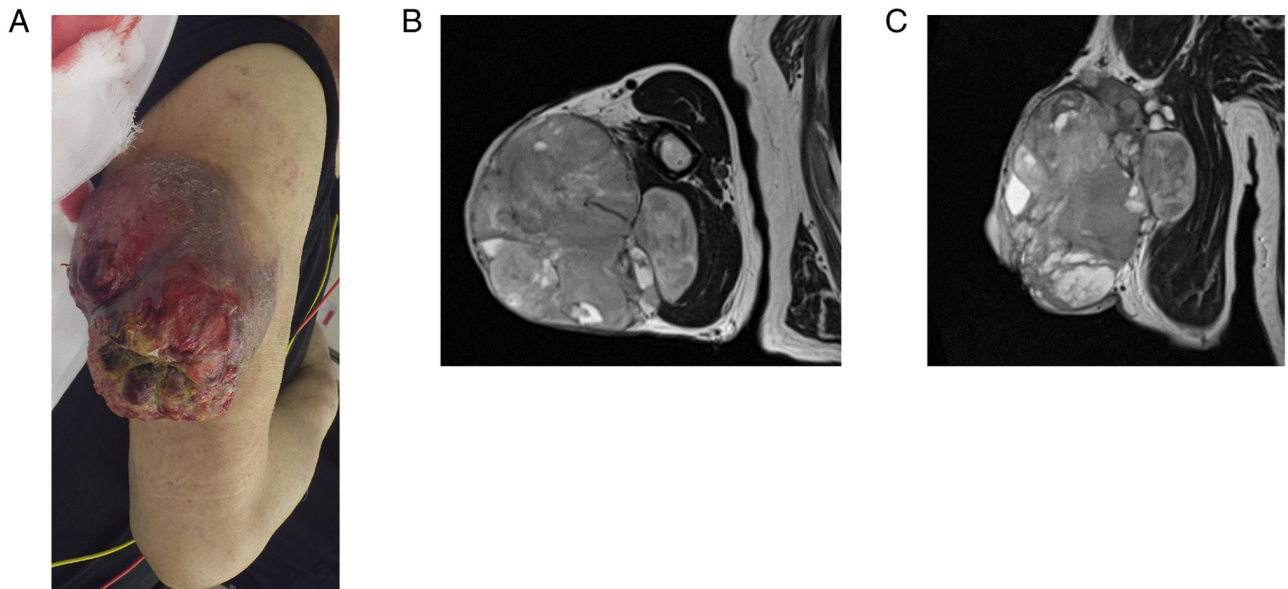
A 78-year-old man with malignant wound from a myxofibrosarcoma in the upper arm. (A) He had a large tumor in his right upper arm with odor and exudate on the wounded overlying skin. (B and C) MRI revealed a mass with high intensity on T2-weighted images.
